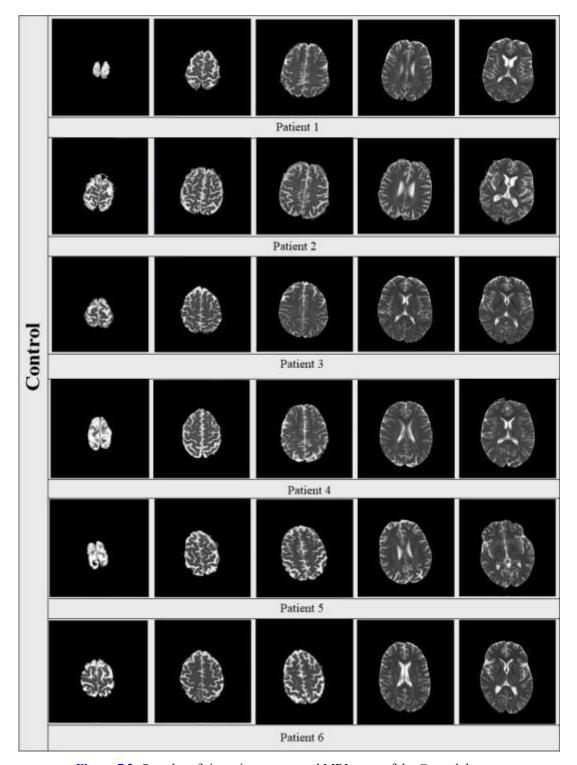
Samples of six patient segmented MRI scans of the Control dataset.
